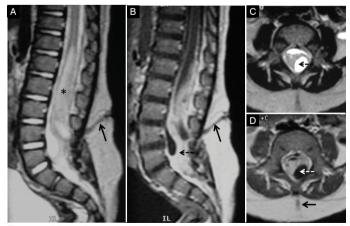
Magnetic resonance images of a 10-month-old boy with lumbar DS (Case 5). The DS tract is identified in the subcutaneous cellular tissue up to the dural sac (black arrows) associated with a tethered spinal cord and aninfected syringomyelia (asterisk and white arrow). A. Sagittal T2 MRI. B. Sagittal T1 MRI with gadolinium. C. Axial T2 MRI. D. Axial T1 MRI with gadolinium.
